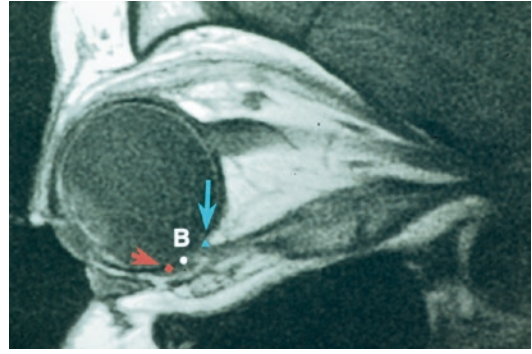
Sagittal MRI of the orbit of a patient with thyroid eye disease 1 day after a 5 mm inferior rectus recession using a semi-adjustable suture technique, taken with the eye in downgaze. The *orange arrow and diamond* indicate the point of tangency of the muscle prior to recession determined by where a line drawn from the origin of the muscle is tangent with the globe. Point B is the post-recession new insertion. The *turquoise triangle and arrow* denote where the global layer (post-recession) loses contact with the sclera. Both Point B and the *turquoise triangle* are well posterior to the point of tangency, and thus there is a complete lack of wraparound effect of the muscle with the globe. If the muscle had not been fixated to the sclera, it would lose apposition to the globe (from Chatzistefanou et al. [7], with permission)
